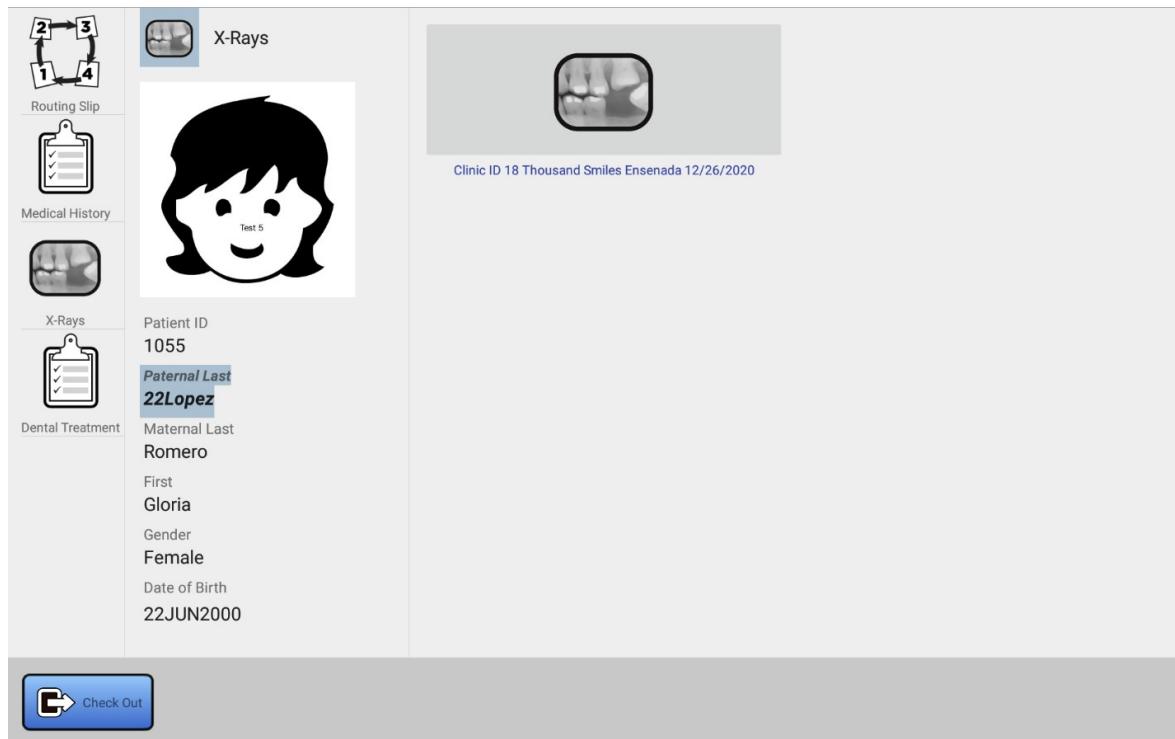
List of X-Ray records for Patient 1055
